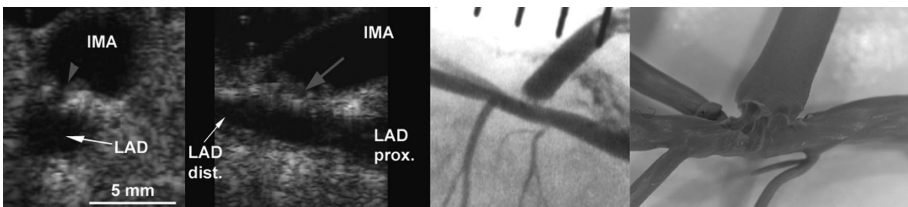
Correctly constructed control anastomosis: transverse (left panels) and longitudinal ultrasound image (right panels). IMA, internal mammary artery; LAD, left anterior descending coronary artery; Prox, proximal; Dist, distal.
